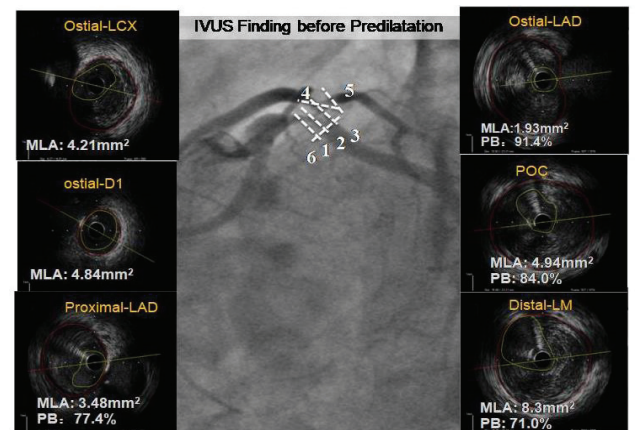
Intravascular ultrasound (IVUS) pullback from left anterior descending artery (LAD), first diagonal and left circumflex artery (LCX).
